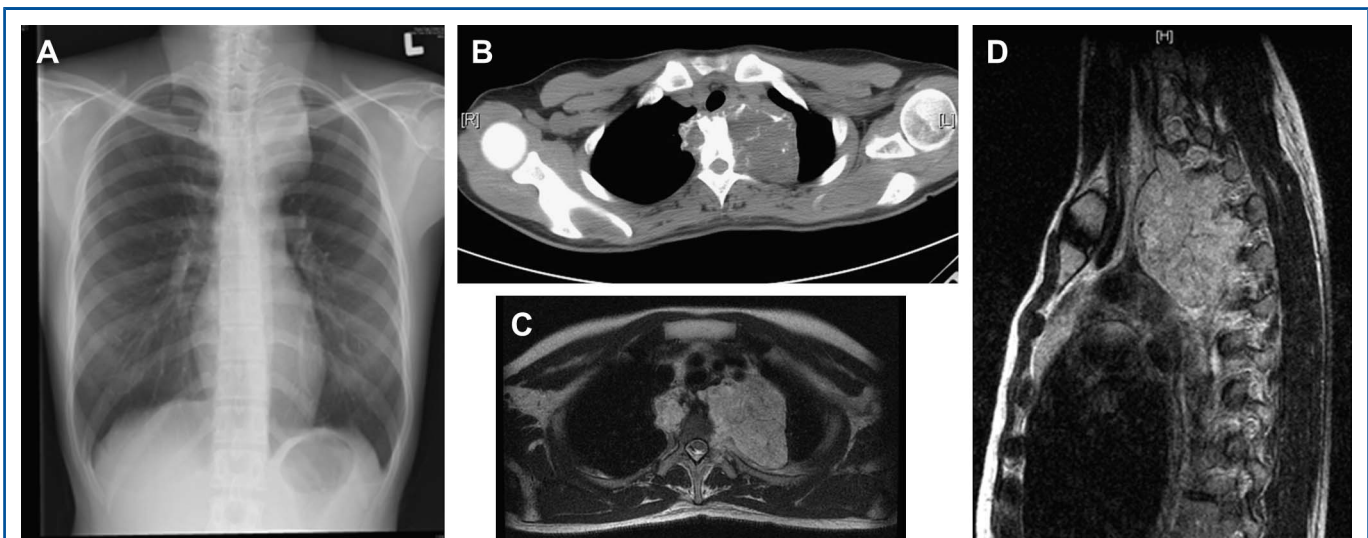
Images of the patient on initial presentation including chest radiograph (A), computed tomography of the chest (B), magnetic resonance imaging of thoracic spine in axial (C) and sagittal (D) planes.
